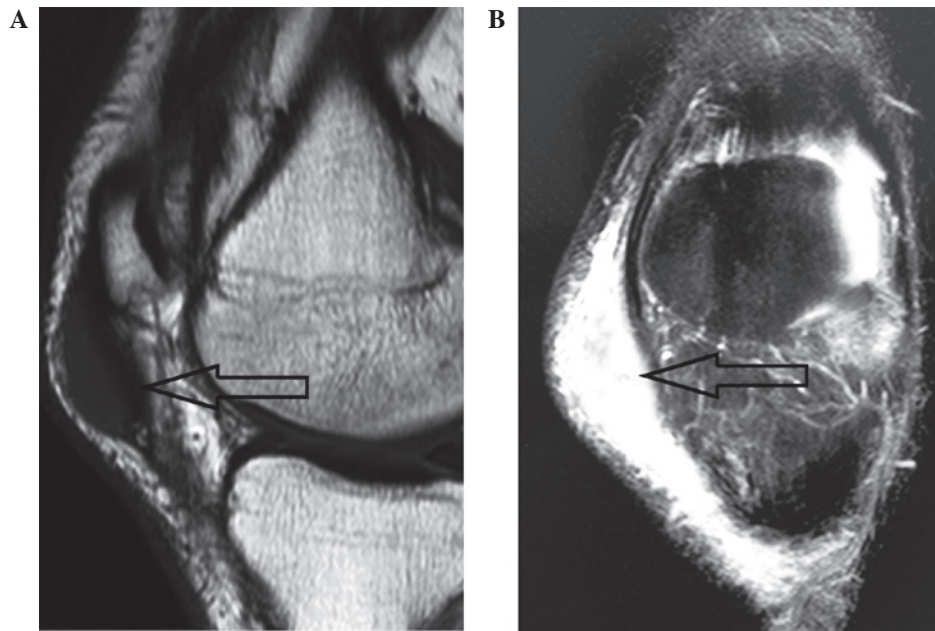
Magnetic resonance images of the patient's left knee. (A) T1-weighted imaging revealed a mass with homogeneous signal isointensity relative to that of muscle. (B) T2-weighted imaging revealed predominantly signal hyperintensity in the mass area. Arrows indicate the mass.
